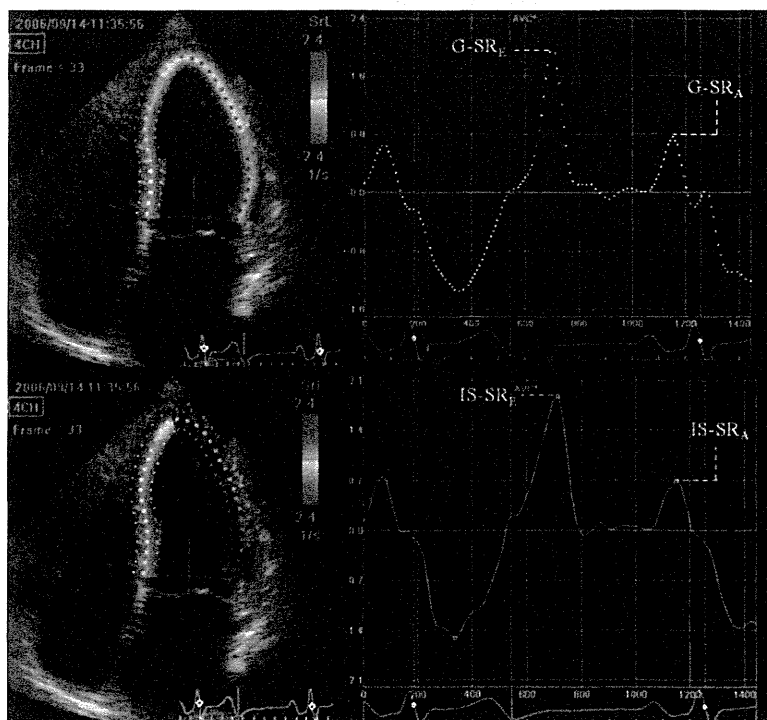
Measurement of myocardial strain rates using two-dimensional speckle-tracking imaging. Left ventricular global strain rates (upper panels): a region of interest for speckle-tracking analysis was set on the entire left ventricular myocardium in the apical four-chamber view (left panel). The peak early diastolic and late diastolic myocardial global strain rates ($G-SR_E$ and $G-SR_A$, respectively) were measured (right panel). The interventricular septal strain rates (lower panels): a region of interest was set on the interventricular septum from the base to the apex (left panel), and the peak early diastolic and late diastolic interventricular septal strain rates ($IS-SR_E$ and $IS-SR_A$, respectively) were measured (right panels).
